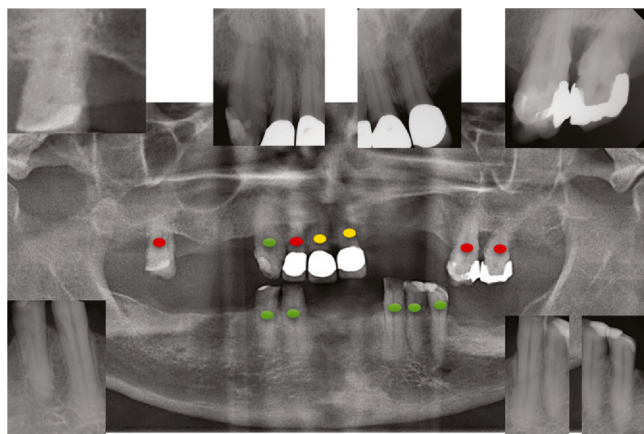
Diagnostic panoramic and periapical radiographs. Tooth prognosis: hopeless (red dot), questionable (yellow dot), and good (green dot).
